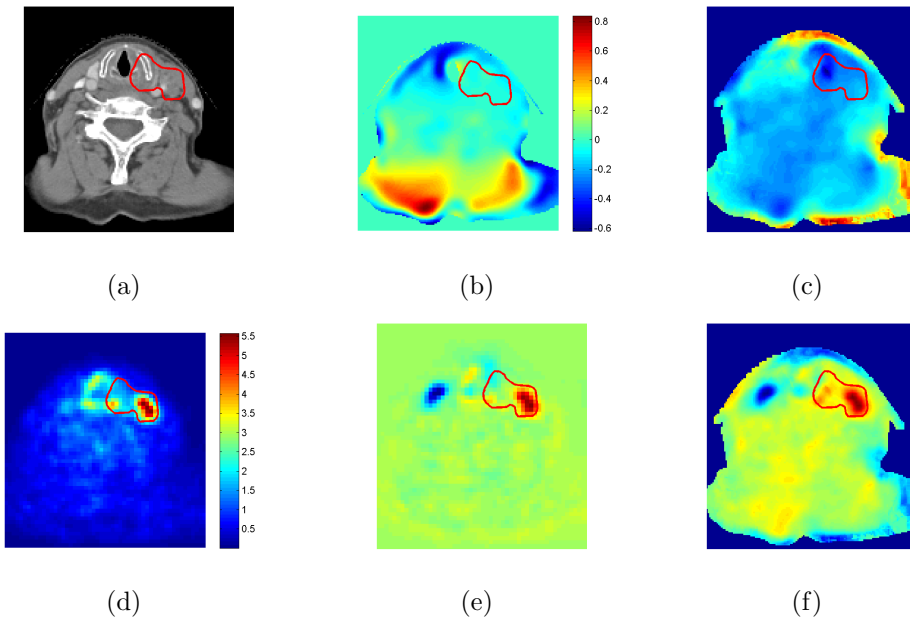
Image results from a patient. (a) the original CT-image. (b) Visualization of the symmetry volume difference, ΔV . The image intensities has been log2 transformed and the background has been set to 0 to emphasize the result inside the patient. (c) A visualization of the normal symmetry probability, P_{sym} . (d) The original PET-image. (e) The symmetry difference of the PET-image, ΔP . (f) the signal of the combination of (b) and (d) used for segmentation. The background has been set to a fixed level in (b-c) and (e-f) to emphasize the signal inside the patient. The red contour is the manual segmentation by the doctors.
